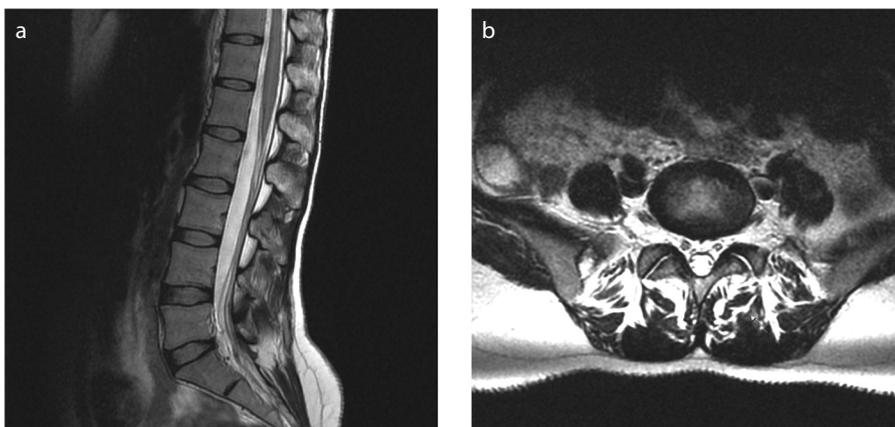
a, b. A 36-year-old male patient with grade 1 LMM atrophy without disc hernia. Midsagittal image (a) shows normal L4-L5 and L5-S1 discs; no significant loss of height or disc hernia is seen. Axial T2-weighted image (b) shows grade 1 LMM atrophy at L5-S1 level.
